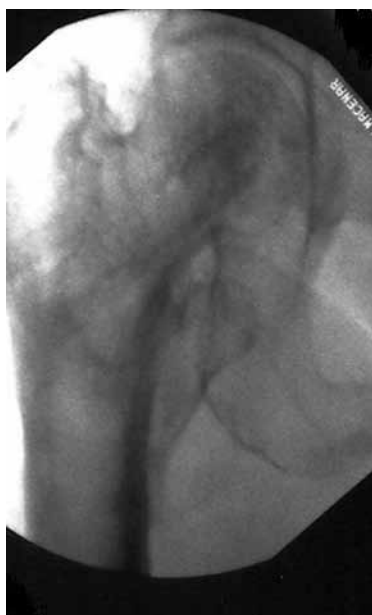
Plain-film x-ray showing the larger-than-usual right lesser trochanter in contact with ischial bone.
